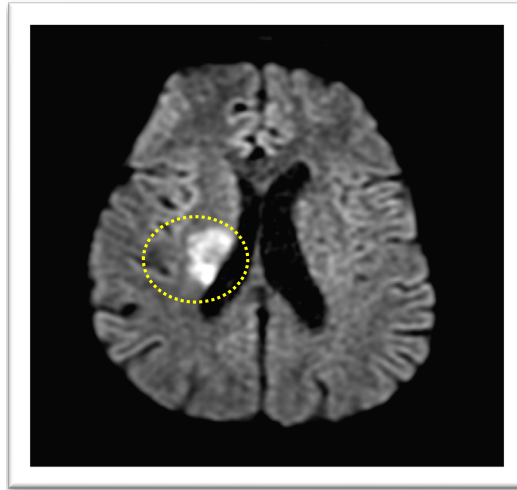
Brain diffusion MRI of Case 7 showing right lateral ventricle lentiform nuclei infarct (as highlighted by yellow dotted circle).
